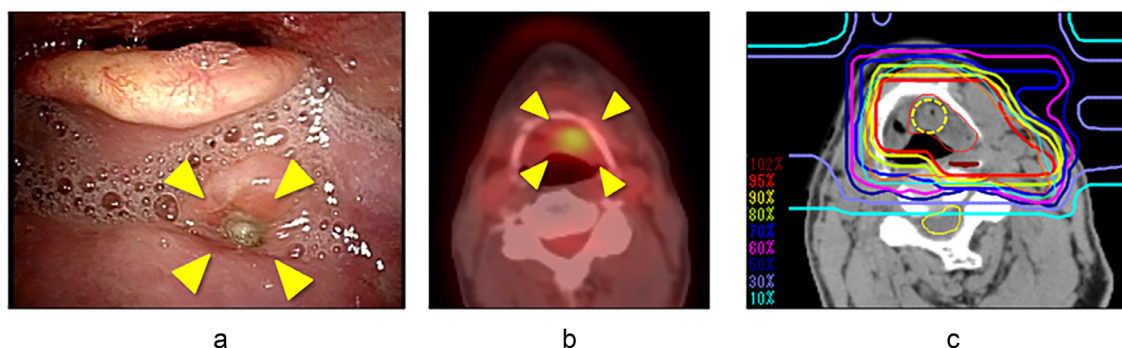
Findings at the time of recurrence. (a) Nasopharyngoscopy: ulcerative changes in tumor localization at initial presentation (yellow arrow). (b) Positron emission tomography– computed tomography (PET/CT): abnormal accumulation (Standardized Uptake Value (SUV) max 3.5) on the left side of the tongue base (yellow arrow). (c) Abnormal PET/CT accumulation was fitted to the dose distribution map of the initial carbon ion radiotherapy (yellow dotted line). Abnormal accumulation was observed within the high-dose region in the irradiation field.
